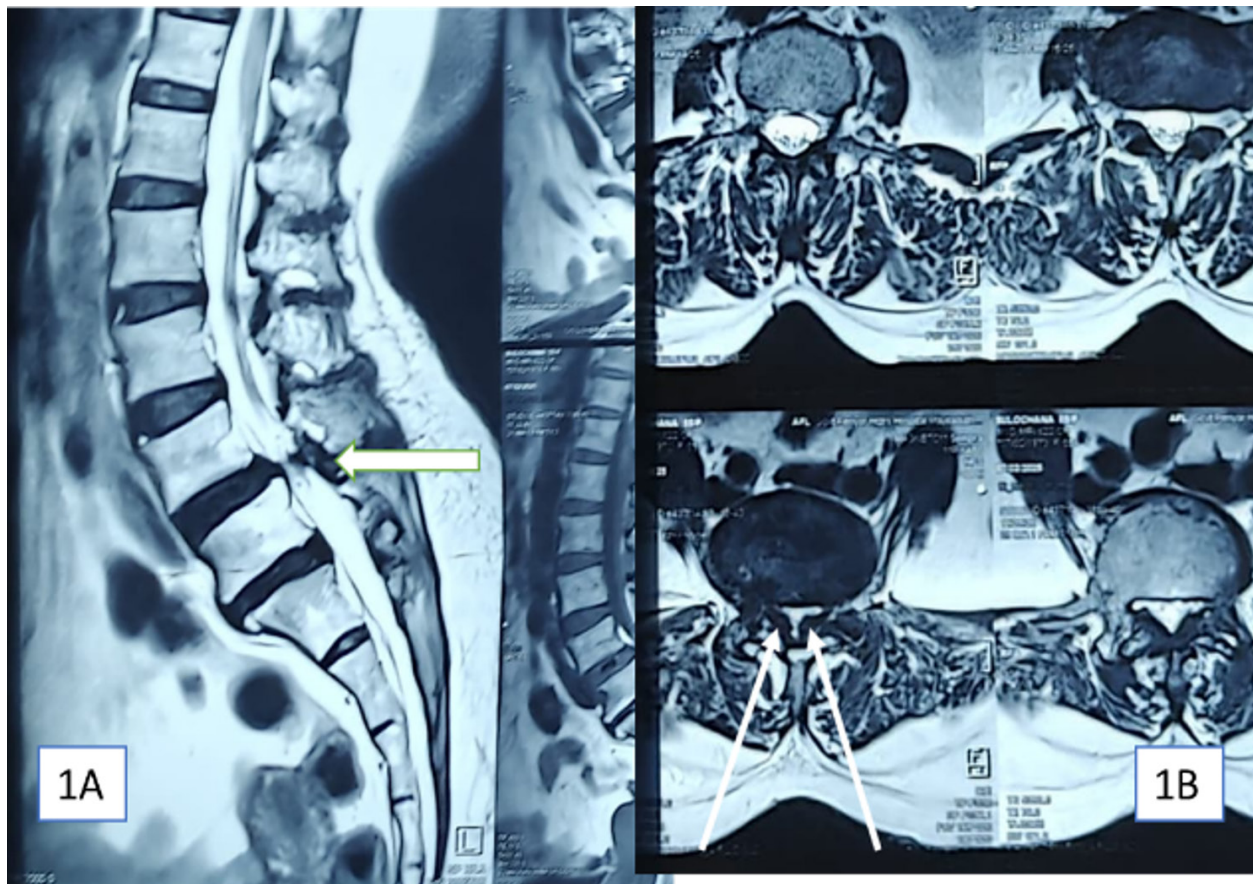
(A) Sagittal T2-weighted image showing hypertrophied LF at L4-L5 (white arrow). (B) Axial image at L4-L5 showing severe LSS due to LF hypertrophy; white arrows show the trajectory of the RF needles.
